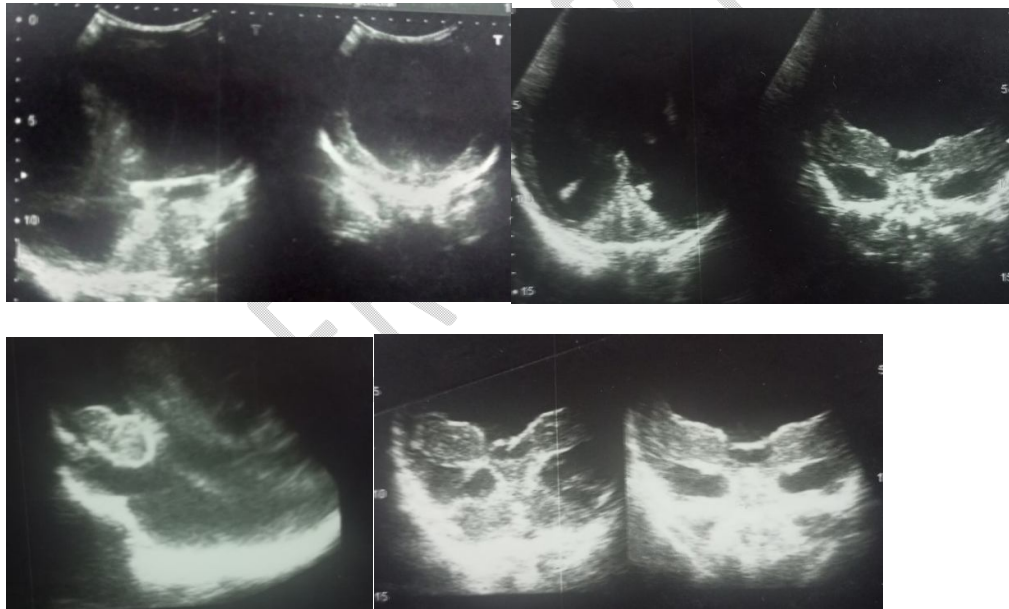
Transfontanellar ultrasound
